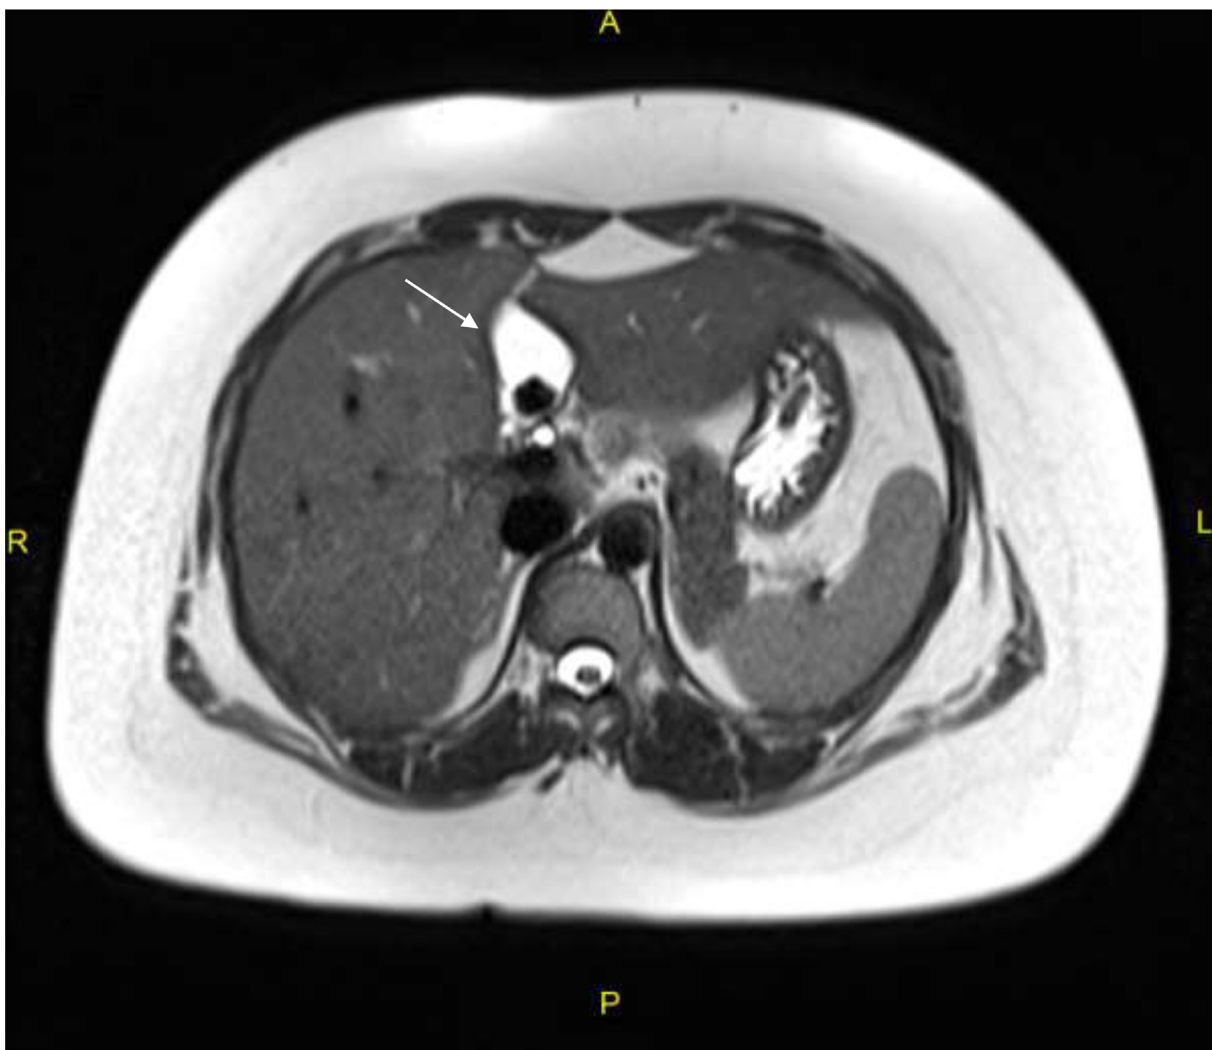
Transverse T2-weighted magnetic resonance image showing the gallbladder (arrow) with a stone inside, located to the left of the fissure for ligamentum teres under segment III.
